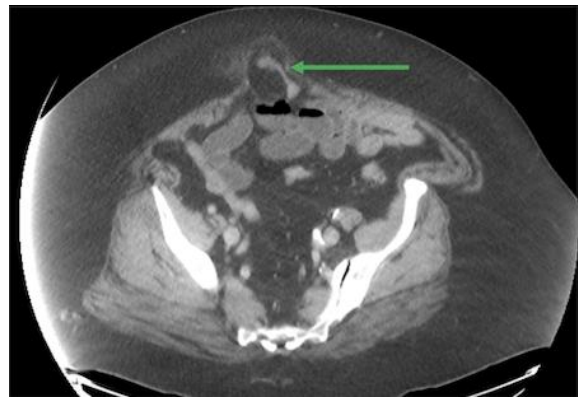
CT scan axial view showing the strangulated bowel (green arrow).
